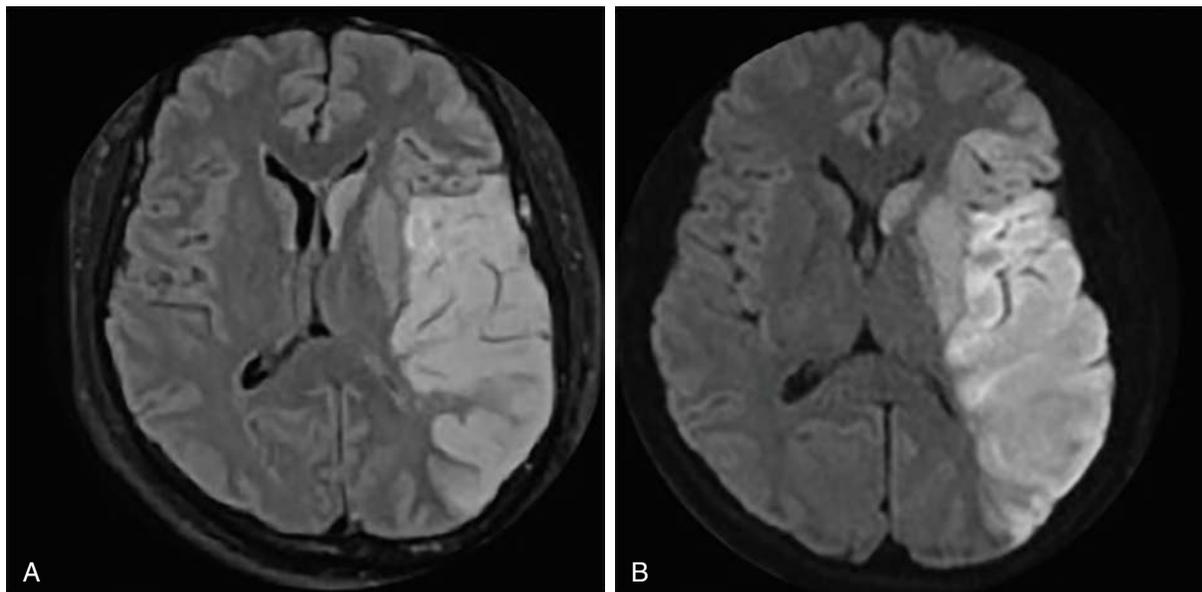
MRI appearance of acute left middle cerebral artery territory infarct. A, FLAIR shows hyperintense cytotoxic edema involving the cortex and subjacent white matter in the left MCA territory with sparing of the left anterior and posterior cerebral artery territories. B, DWI shows increased signal intensity corresponding to the area of cytotoxic edema seen on FLAIR.
